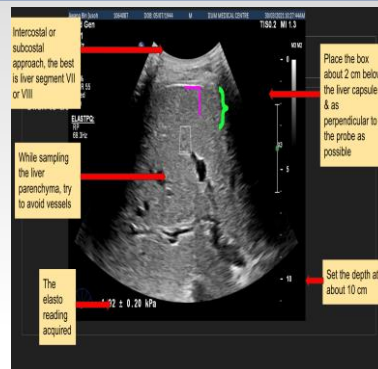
shows how to perform Ultrasound Elastography using shearwave elastography technique by the Philips Ultrasound machine. 10 readings will be measured. The machine will calculate the average measurement for the final result.
